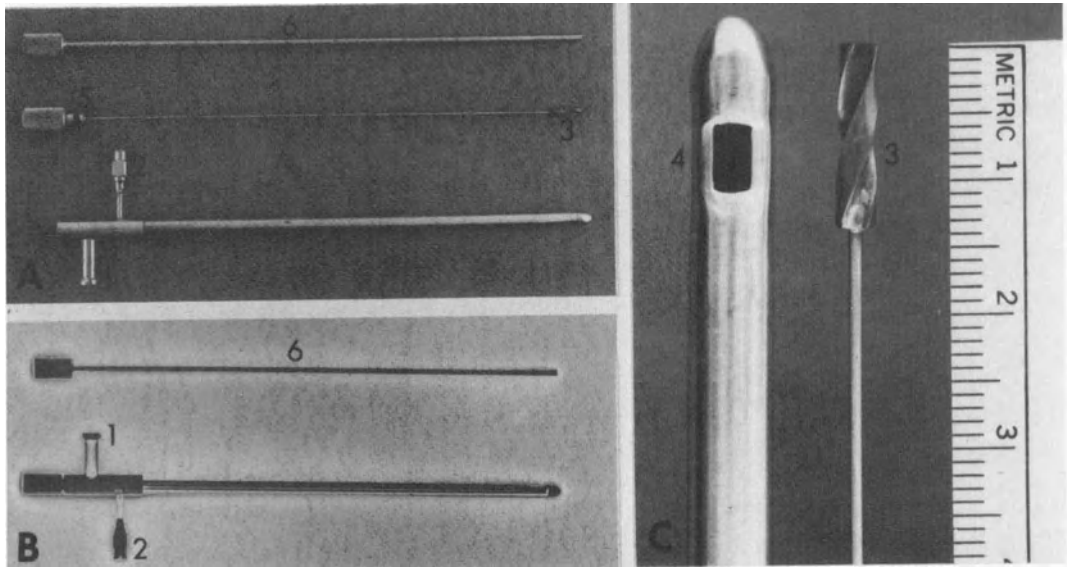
(A) Higgins-Nashold instrument. (B) Radiograph of instrument with mandrel in place. (C) Magnified view: 1. aspiration port (A and B); 2. standard connection for intravenous fluid tubing on irrigation channel (A and B); 3. helical cutting mandrel (A and C); 4. side cutting port (C); 5. O-ring seal (A); 6. Obturator (A and B).
